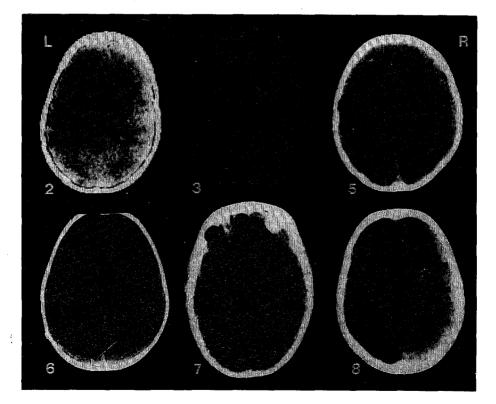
CT scans of 6 patients with head injury.
